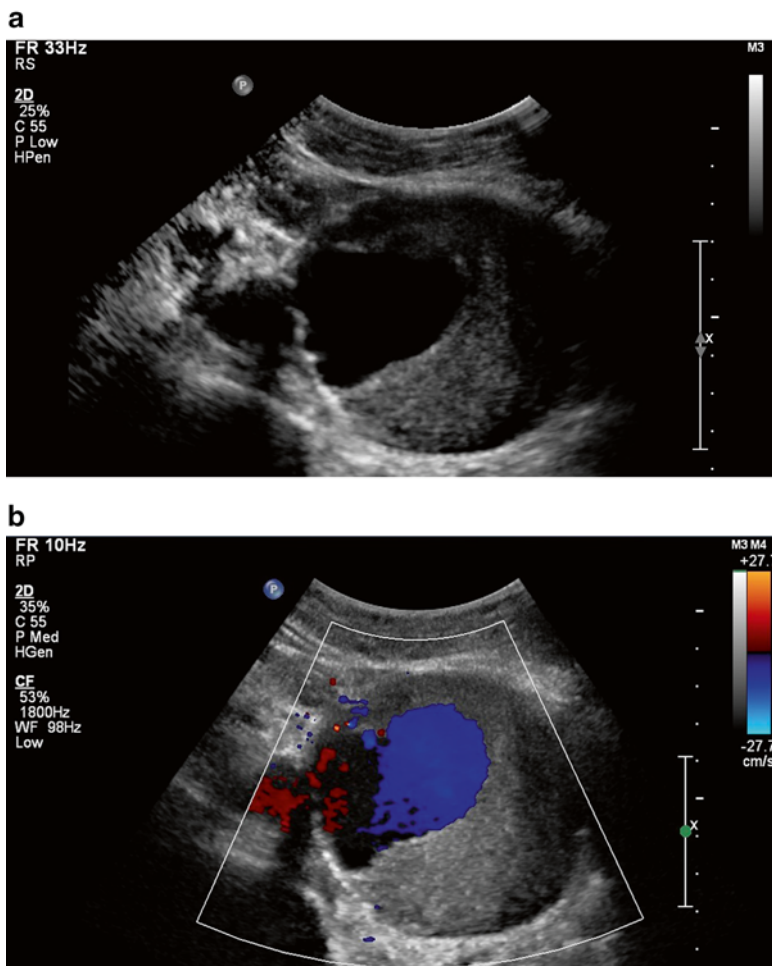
An abdominal aortic aneurysm with a mural thrombus, images here taken in B Mode (a) and with color Doppler (b)
